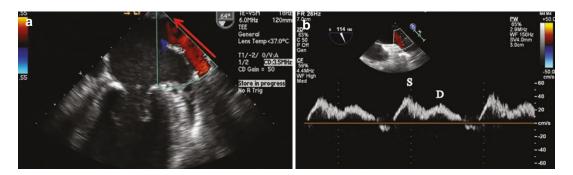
(a) Upper esophageal LUPV view with color flow Doppler demonstrating LUPV flow (*red arrow*). (b) Pulsed-wave Doppler assessment of the right upper pulmonary veins in the upper esophageal right pulmonary
